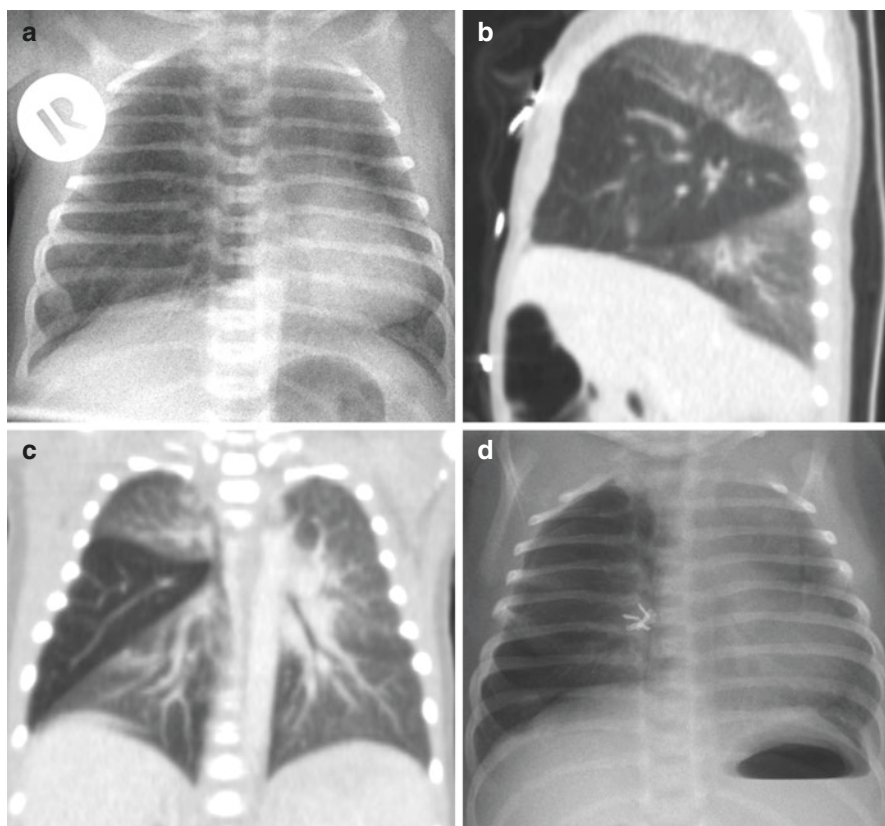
Congenital lobar emphysema in a 4-week-old newborn. Conventional X-ray with an overexpansion of the right lung (a). Corresponding CT scan with the pathology in the middle lobe (b, c). Postoperative X-ray after thoroscopic middle lobe resection (d)
